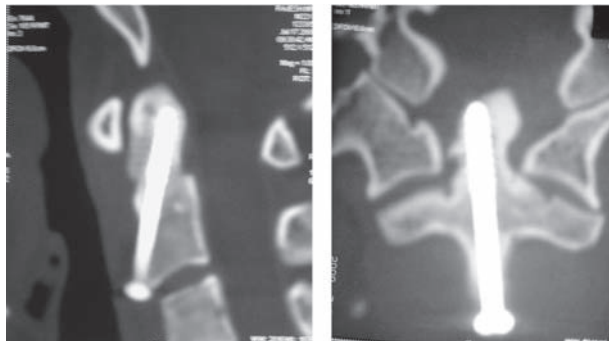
CT scan of cervical spine (Sagittal and Coronal section) showing good fusion at the fracture site.
